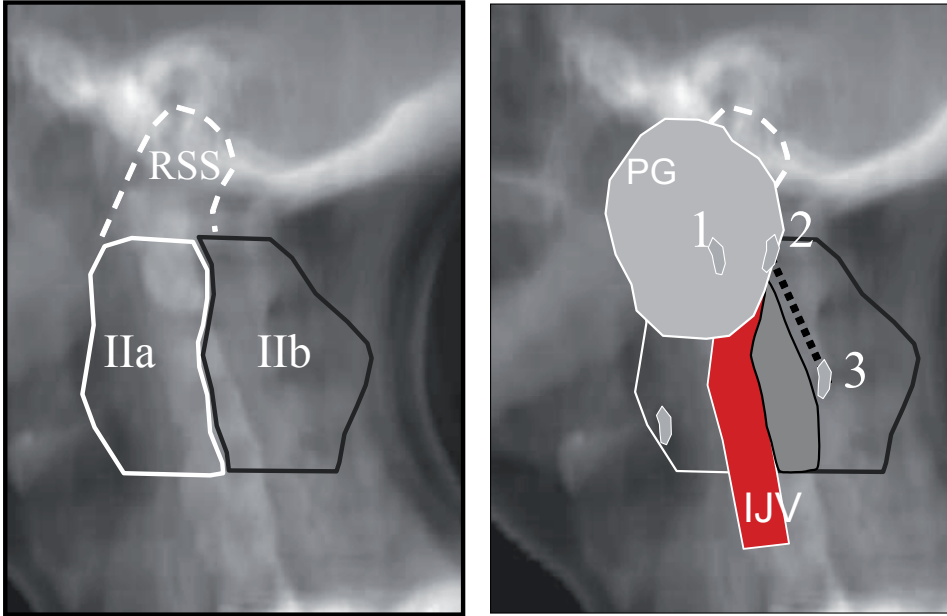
Digitally reconstructed radiograph (left panel) is shown of the computed tomography (CT)-based contoured sublevels IIa and IIb, and the retro-styloid space (RSS). Right panel: superimposed on the delineated sublevels, the contoured IJV and the clips positioned intra-operatively at the relevant surgical boundaries of sublevels IIa/IIb and the hyoid (clips #1, #2, #3, #5). The stipulated line demarcates the position of the boundary between the surgically defined sublevels IIa and IIb (SAN). The “no-man’s land” zone is the triangularly shaped, cross-hatched area between the posterior border of the surgically defined sublevel IIa (SAN) and the posterior border of the CT-based level IIa (posterior boundary of the IJV). *I.J.R.O.Biol. Phys* 2005;62:3:690-699.
